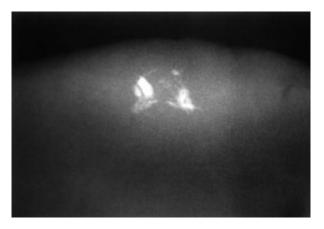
Presence of tooth fragments in the lower lip revealed by periapical radiograph.
